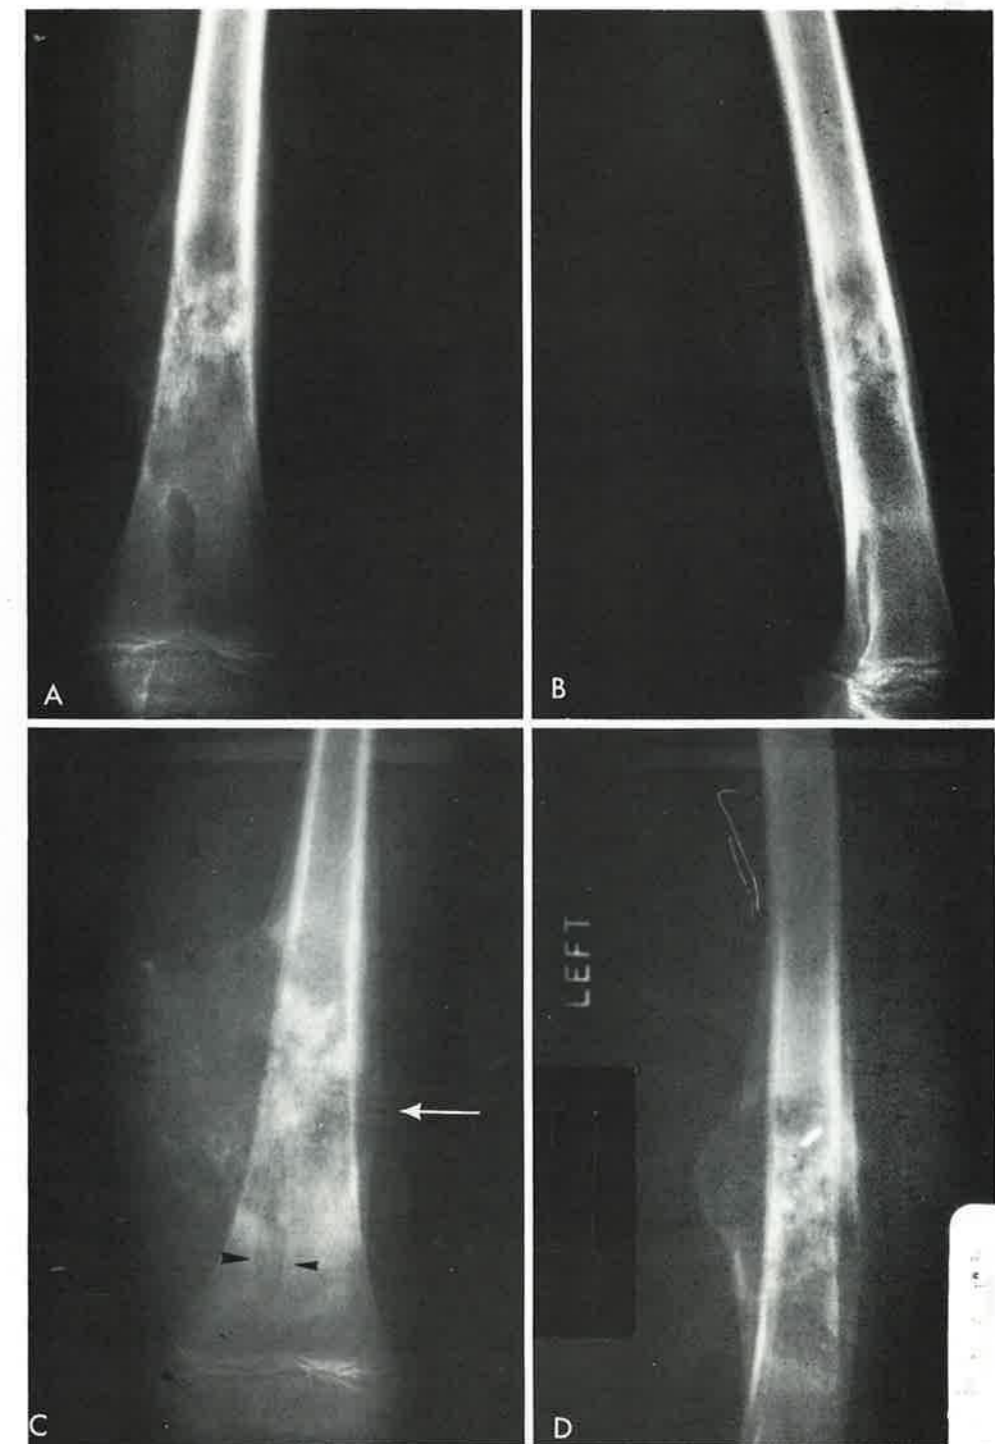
Conversion of a lamellated continuous reaction into a lamellated interrupted periosteal reaction. Osteosarcoma of femur in an eight year old boy. The interval of time between radiographs A and B versus C and D is 20 days. What was originally a continuous reaction on the posterior surface B is interrupted by the extraosseous extension of tumor (D). A comparison of A and C shows progression of the lamellated reaction along the lateral aspect of the femur, with early tumorous encroachment distally in C (arrow). The distal ovoid lucency (arrowheads) is probably an incidental benign lesion, such as a fibrous cortical defect. (AFIP Neg. No. 79-5920.)
